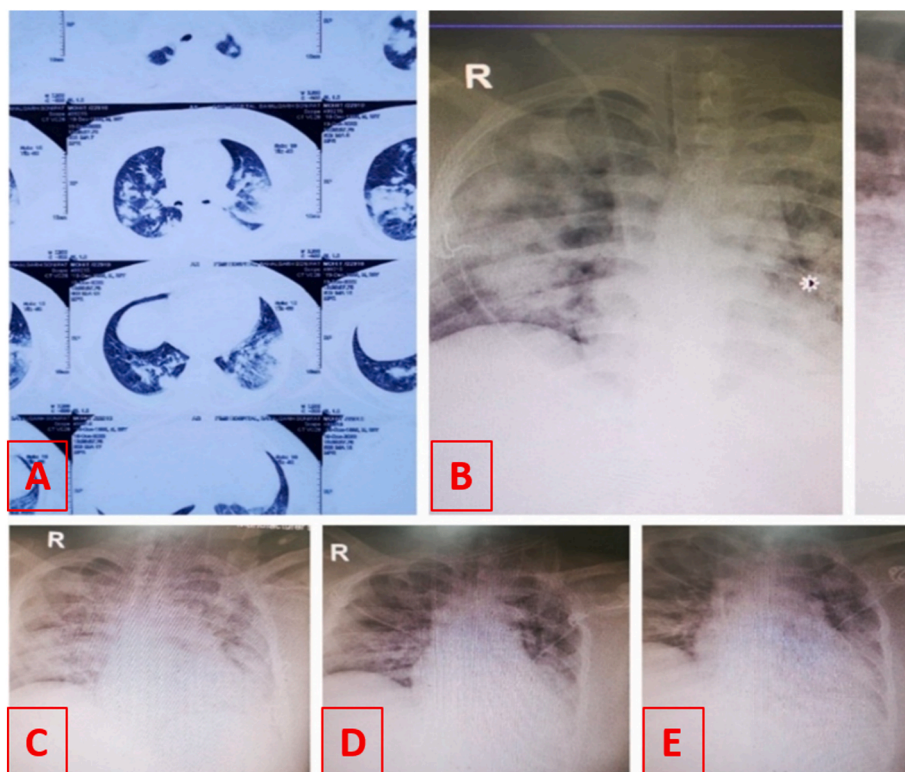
HRCT scan of case 2 showing bilateral infiltrates (A) with successive clearance of shadows (from B to E).
